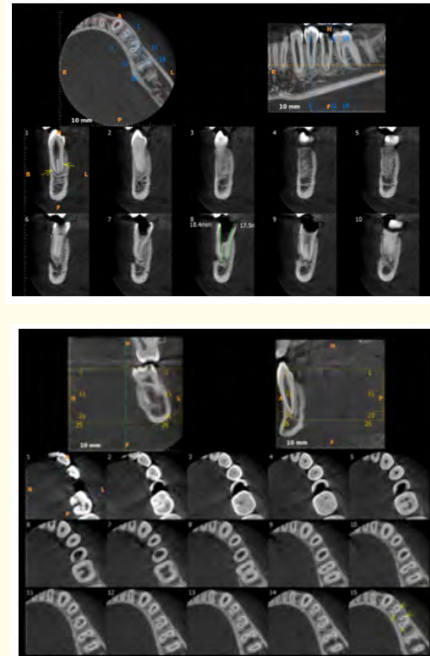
CBCT a. Axial view, b. cross section.
